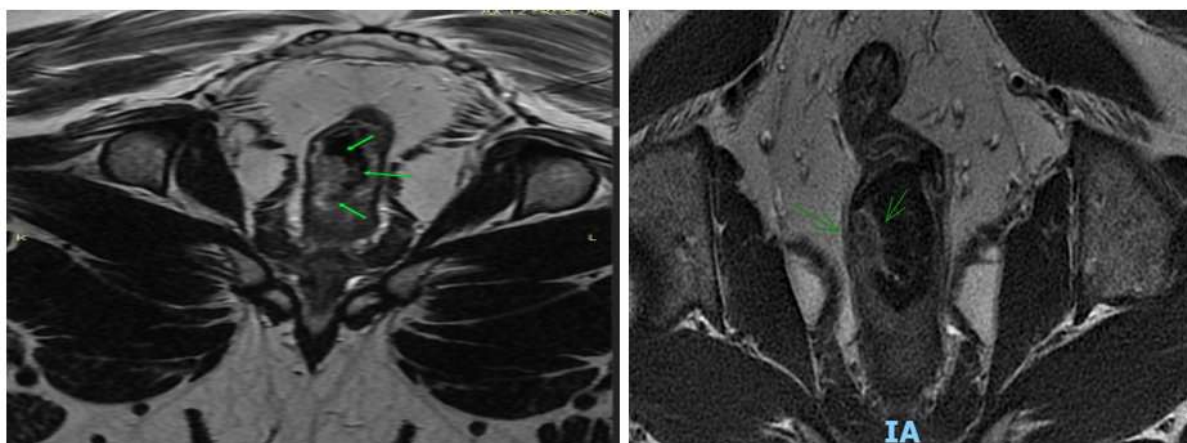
a) T2 coronal plane (06/04/2021) without procedures, had already started ozone therapy before the first MRI; b) T2 coronal view (06/21/2021) post-treatment with ozone therapy: Significant decrease in tumor size (green arrows).
